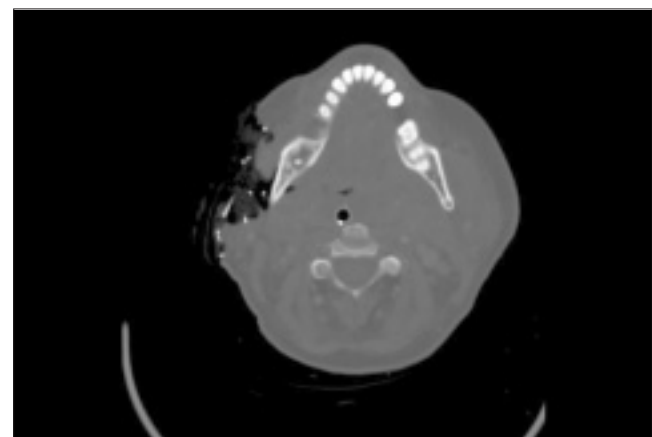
Postoperative CT scan showing resolution of the infection and the defect of the right face by resection of the necrotic tissue.
